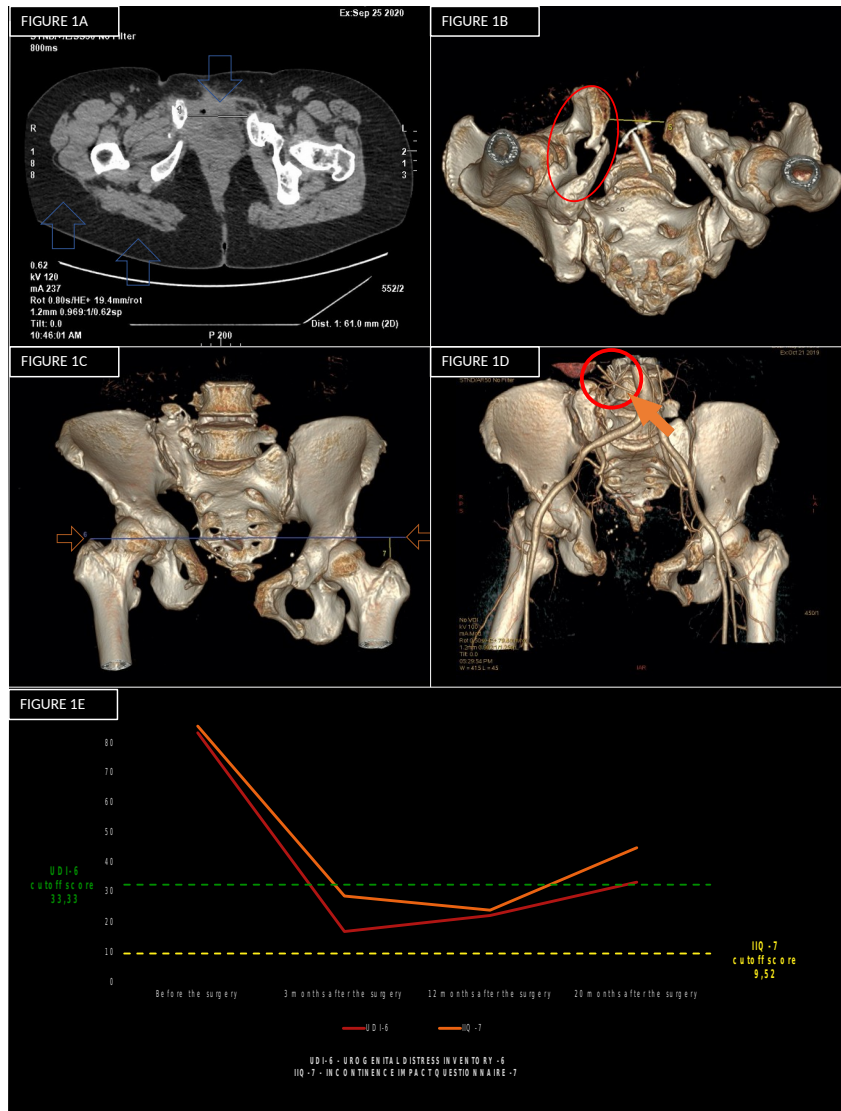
A. Computed tomography (CT) scan of the pelvis; B. CT image of displaced fracture of the inferior right pubis ramus; C. CT image showing the difference in the positions of great trochanters; D. 3D CT angiography showing location of great vessels; E. Changes in the total UDI-6 and IIQ-7 scores before and after the surgery
